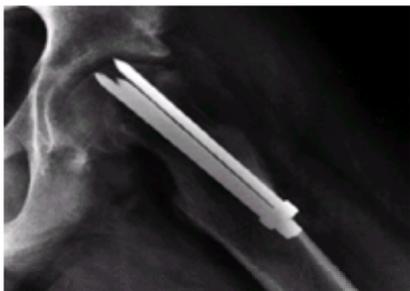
Frog-leg lateral hip radiograph, in a patient with slipped capital femoral epiphysis, demonstrates multiple pin fixation from a lateral starting position. The hardware is not maintained in the center of the femoral head, but rather is confined to the vulnerable anterosuperior quadrant. Penetration of the femoral head and early segmental osteonecrosis are demonstrated.
